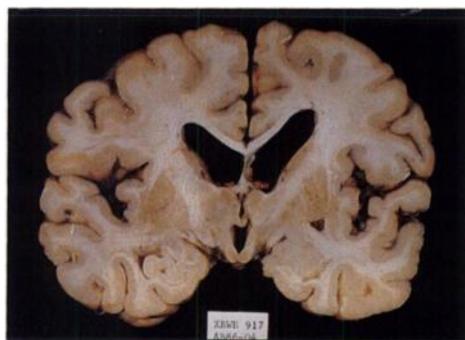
Postmortem coronal slice at the level of the mammillary bodies from a patient with PSP (left) reveals a grossly normal cortical ribbon and mildly enlarged lateral and third ventricles. This patient's corresponding coronal SPECT image (right) demonstrates markedly reduced frontal lobe perfusion.
